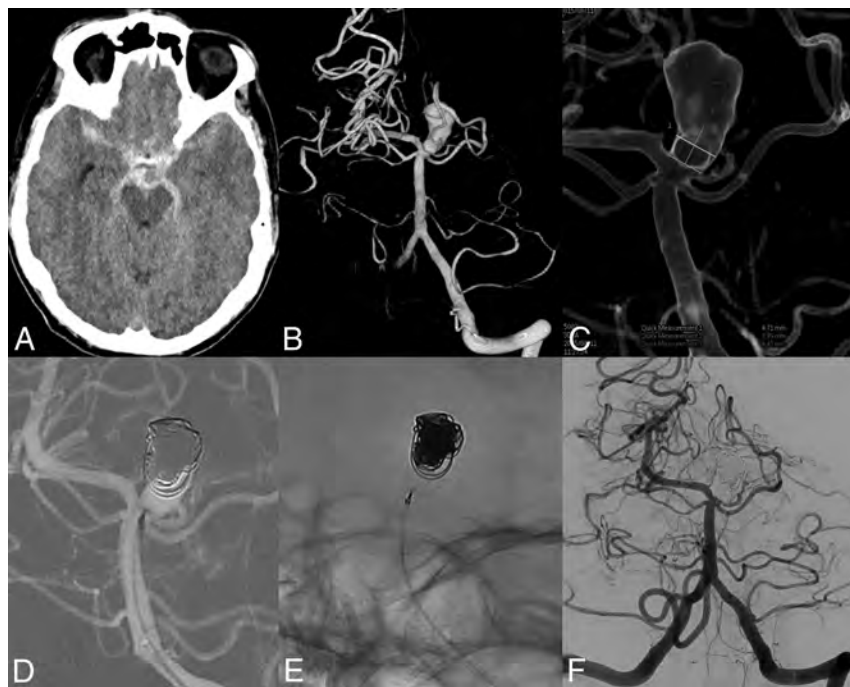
A 61-year-old man with a ruptured basilar tip aneurysm treated with the WEB and coils. A, CT scan with subarachnoid blood. B, 3D angiogram reveals a 13-mm basilar tip aneurysm. C, Neck measurement on a 3D angiogram. D and E, After placement of coils in the dome and a WEB-SL, 6 × 3 mm, in the neck. F, Three-month follow-up angiogram with complete occlusion.
